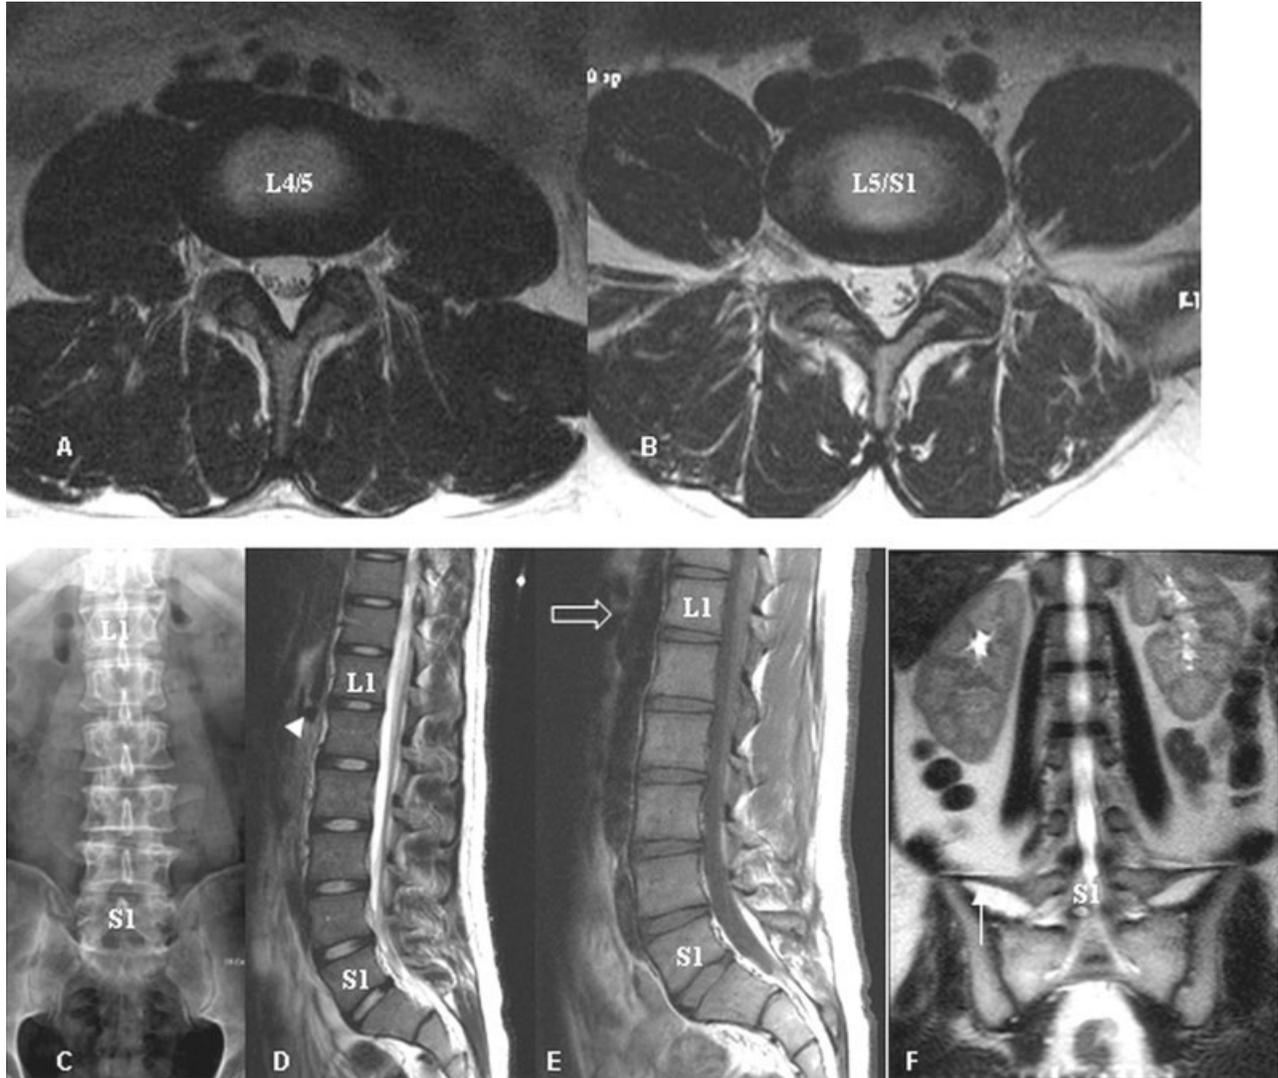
Forty-eight-year-old man with S1 lumbarization. Note that the paraspinous structures are located more caudally than normal. A: Axial T2 WI shows aortic bifurcation at the level of the L4-5 disc space. B: Axial T2 WI shows IVC confluence at the level of the L5-S1 disc space. C: In the lumbar AP radiograph, the S1 vertebra shows complete lumbarization. D: Sagittal T2 WI shows the proximal right renal artery (arrow head)
